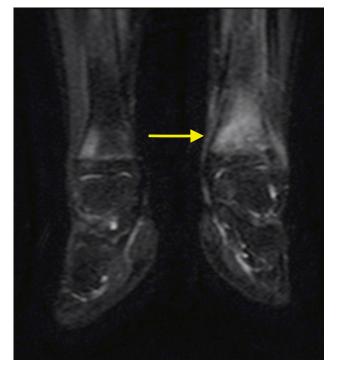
Ankle section of T2-short time inversion recovery (STIR) whole-body magnetic resonance image of a patient with chronic recurrent multifocal osteomyelitis. The *arrow* shows hyperintensity of bone with edema of soft tissues. The patient presented with clinical involvement of both mandible and ankle
